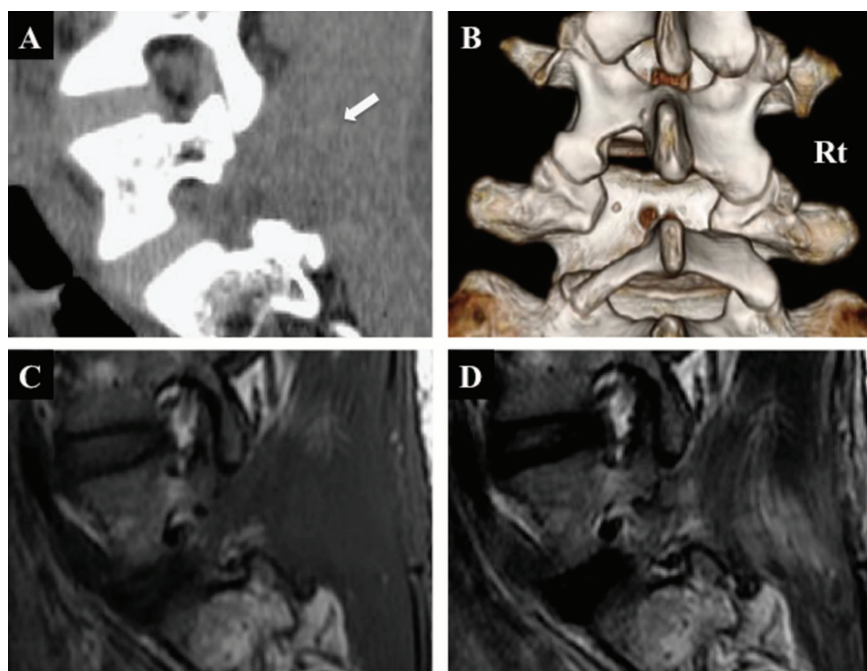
Computed tomographic (CT) scans obtained 5 days and magnetic resonance images obtained 3 months postoperatively, showing no residual lesion and no apparent instability. Sagittal CT scan (A), 3-dimensional CT scan (B), sagittal T1-weighted image (WI) (C), and sagittal T2-WI (D).
